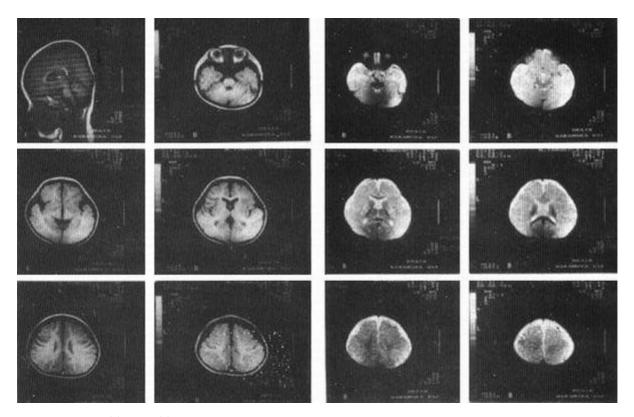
Transaxial T1(a) and T2(b) Weighted spin echo MR images with mild frontal atrophy and enlarged subdural space bliaterally, otherwise normal MR images.
